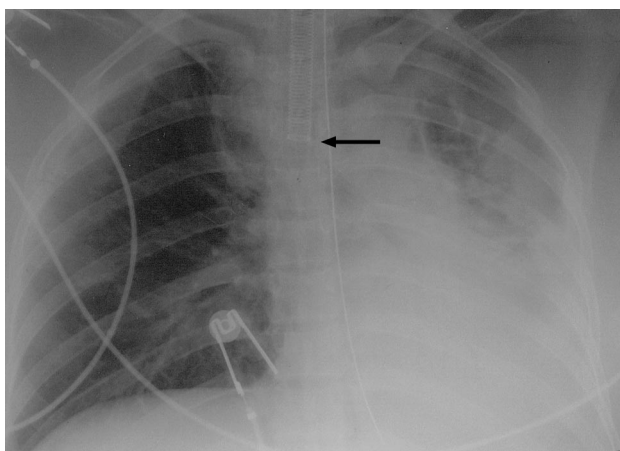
Radiograph showing atelectasis of the left lung. The wire coil in the endotracheal tube (ETT, arrow) ends above the main carina, but the end of the ETT is 3 cm beyond the end of the wire coil.
